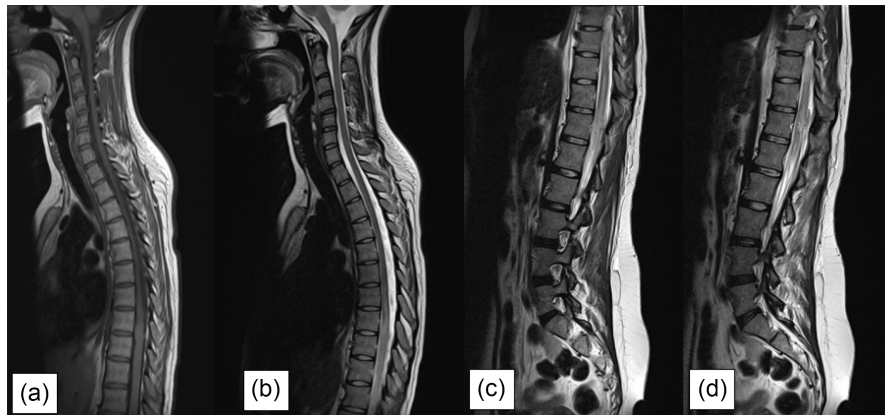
Sagittal T1 slices (a) and sagittal T2 slices ((b), (c), (d)) of a spinal MRI showing an increase in spinal cord diameter with a T2 hyperintensity extending from T7 to L1.
